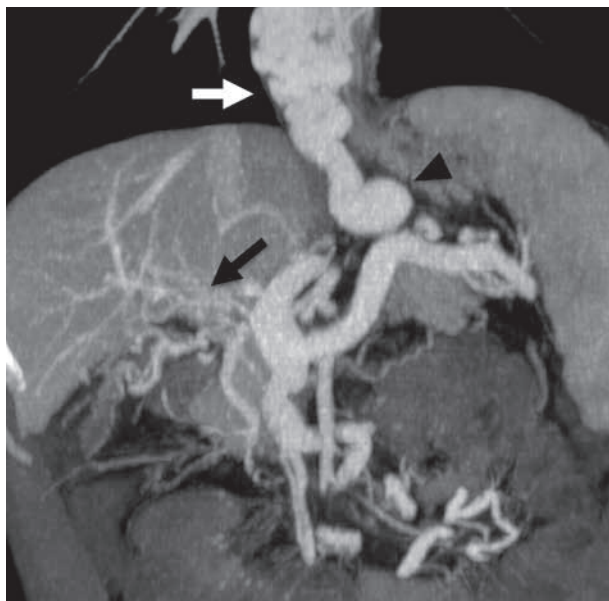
Maximum intensity projection coronal portal venous CT of the upper abdomen demonstrates cavernous transformation of the portal vein (black arrow), and profuse oesophageal varices (white arrow) supplied by an enlarged left gastric vein (black arrowhead). Splenomegaly is also present.
